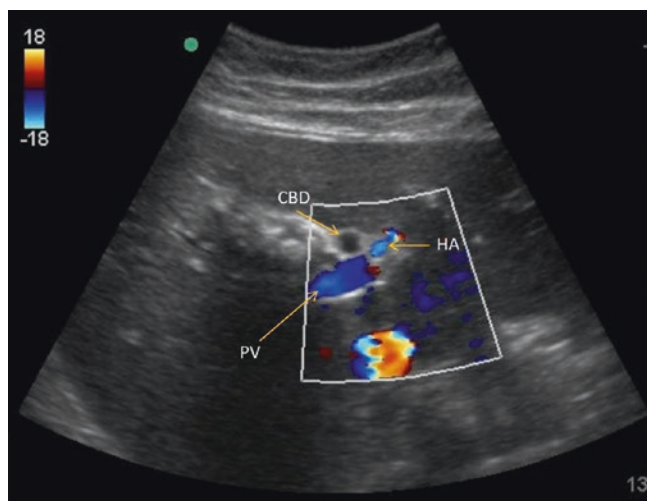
Color flow Doppler of the portal triad in a transverse view. Color flow doppler can be used to differentiate common bile duct from hepatic artery and portal vein. The hepatic artery and portal vein will demonstrate flow and the common bile duct will not. *CBD* common bile duct, *PV* portal vein, *HA* hepatic artery. Image courtesy of Bret Nelson
